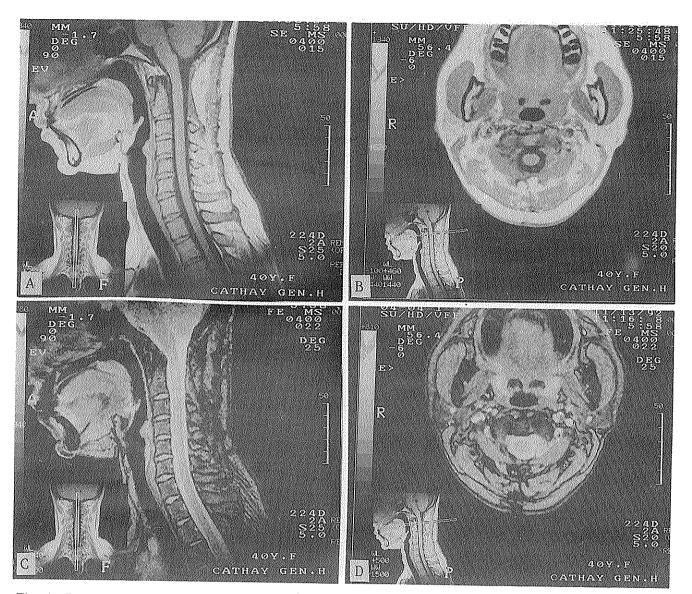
Postoperative MRI showing no recurrence of the tumor and good recovery of previously compressed cervical cord (A, sagittal, and B, axial T1W images; C, sagittal, and D, axial T2*W images).
